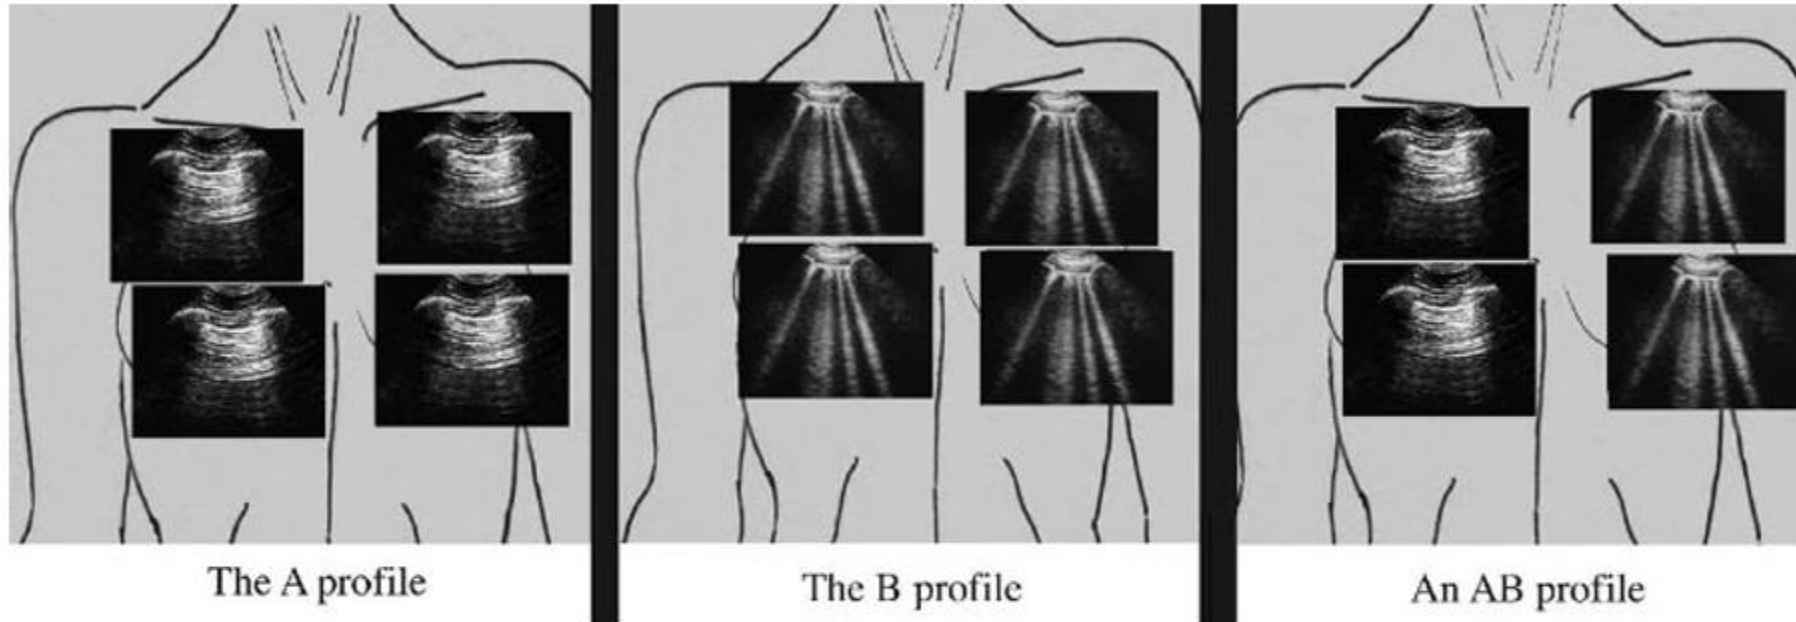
Ultrasound profiles. *Left panel:* The A profile is defined as predominant A lines plus lung sliding at the anterior surface in supine or half-sitting patients (stage 1/1'). This profile suggests COPD, embolism, and some posterior pneumonia. Pulmonary edema is nearly ruled out. *Middle:* The B profile is defined as predominant B + lines in stage 1. This profile suggests cardiogenic pulmonary edema, and nearly rules out COPD, pulmonary embolism, and pneumothorax. *Right panel:* an A/B + profile, massive B lines at the left lung, A lines at the right lung. This profile is usually associated with pneumonia.
